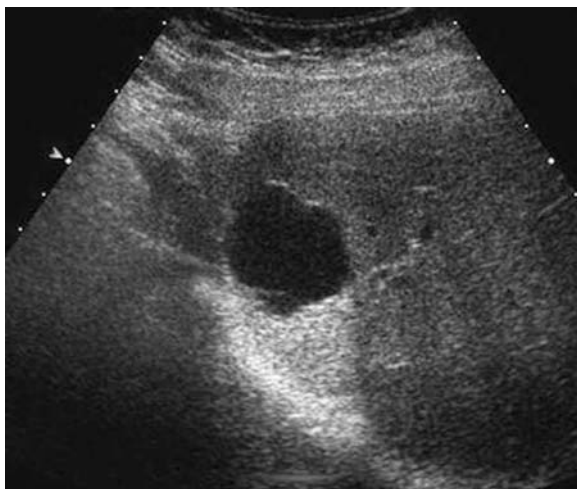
Simple cyst. Ultrasonogram showing the characteristic changes of absence of echoes within the lesion, a distinct far wall, and increased echogenicity posterior to the cyst.
